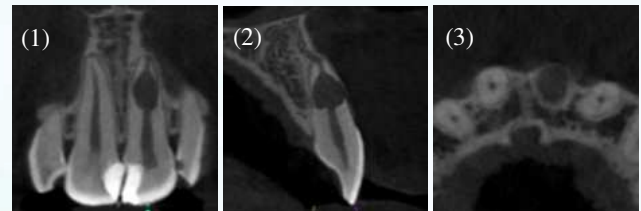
CBCT images of tooth #21 from (1) Coronal. (2) Sagittal (3) Axial section.
